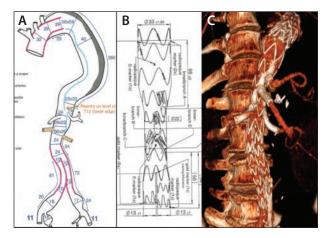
A postdissection TAAA with small true lumen, the celiac trunk arising from the false lumen, stented renal arteries, and a previous aorto-bi-iliac graft. Preoperative sizing with localization of the reentry tear C (A). An E-xtra DESIGN ENGINEERING stent graft with four inner branches and an integrated bifurcation. The plan was to first place a thoracic stent graft in the elephant trunk and distally in the false lumen. The second step was to open the proximal part of the E-xtra DESIGN ENGINEERING in the thoracic stent graft and in the false lumen up to the branch for the celiac trunk. The distal part was planned to open in the true lumen (B). The postoperative 3D CT showed no leak and conformability of the E-xtra DESIGN ENGINEERING. Long bridging stents were required for the renal arteries (C).
